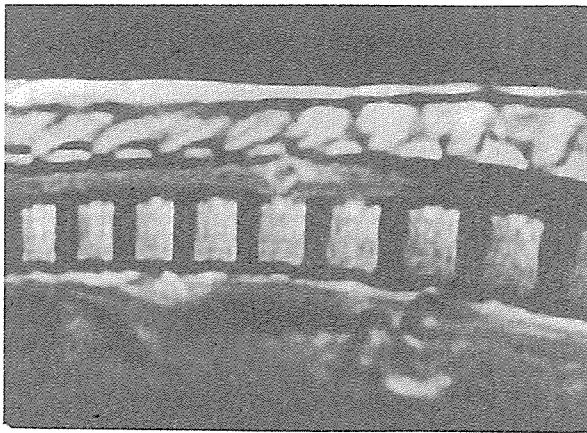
A. Midsagittal T1-weighted MR shows lower dorsal intramedullary hyperintense lesion. There exists a local swelling.
